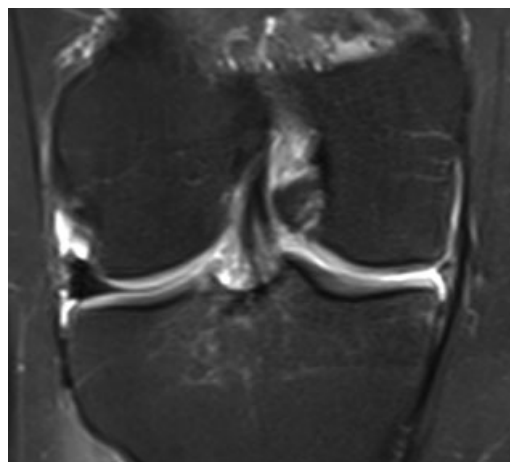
Right knee magnetic resonance imaging of patient status post medial meniscectomy with maintained articular cartilage.
